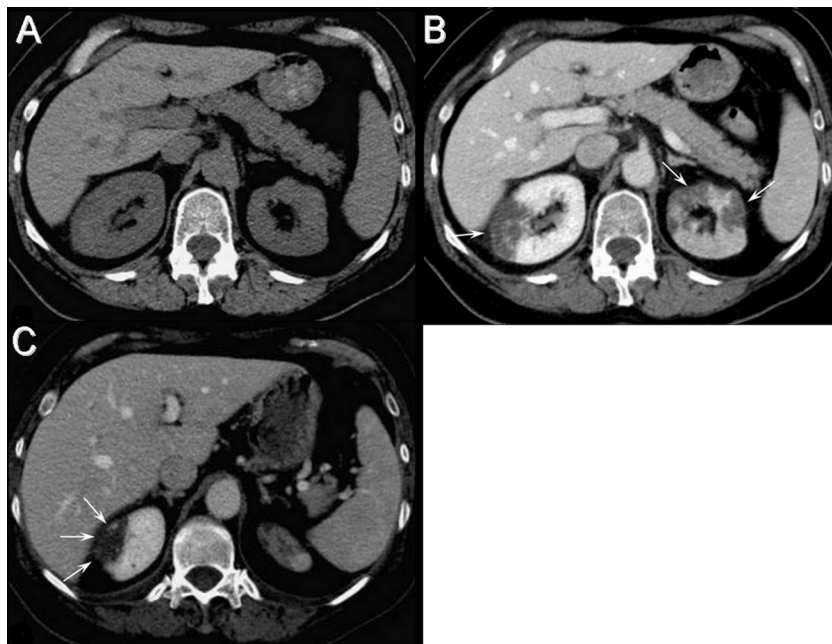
Unenhanced and multi-phase enhanced helical computed tomographic (CT) scans obtained 4 days into hospitalization. (A) Precontrast CT scan shows homogeneous attenuation of kidneys and no calcifications. (B) Nephrographic contrast-enhanced phase demonstrates multiple focal wedge-shaped areas of decreased enhancement in both mid-kidneys with loss of corticomedullary differentiation (arrows). The left kidney demonstrates global decreased uptake of contrast material. Note the normal and homogeneous aspect of fat around the kidneys, with no stranding or fluid collections throughout the perinephric space. (C) Nephrographic enhanced scan shows a thin rim of capsular enhancement (the cortical rim sign; arrows), a finding consistent with a focal infarct.
